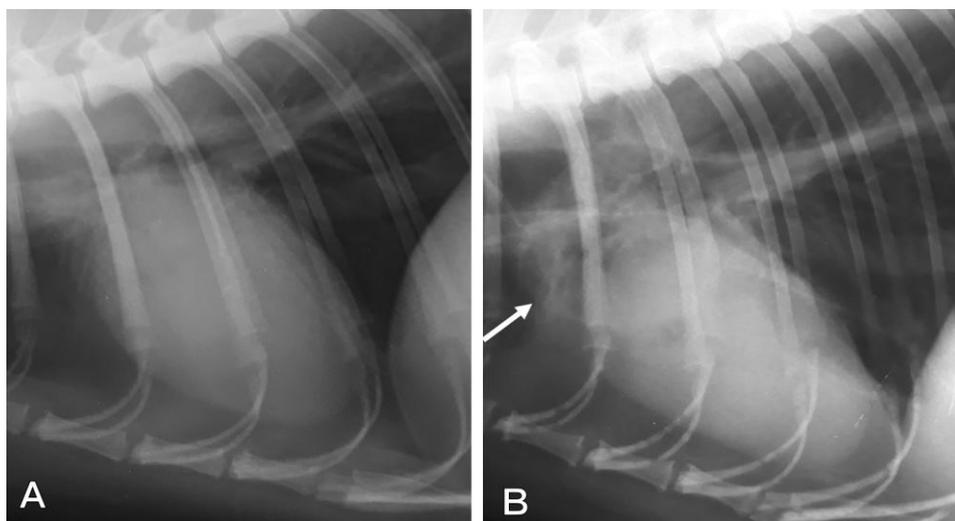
Close-up right lateral (RL) thoracic radiographs of caracal II at the age of 1.2 years (A) and 8.8 years (B). Note the elongated and more horizontally positioned cardiac silhouette in B compared with A. The redundant aortic arch is indicated by a white arrow. The trachea is seen with mineralised cartilage rings and the carina is located at the level of the sixth rib.
